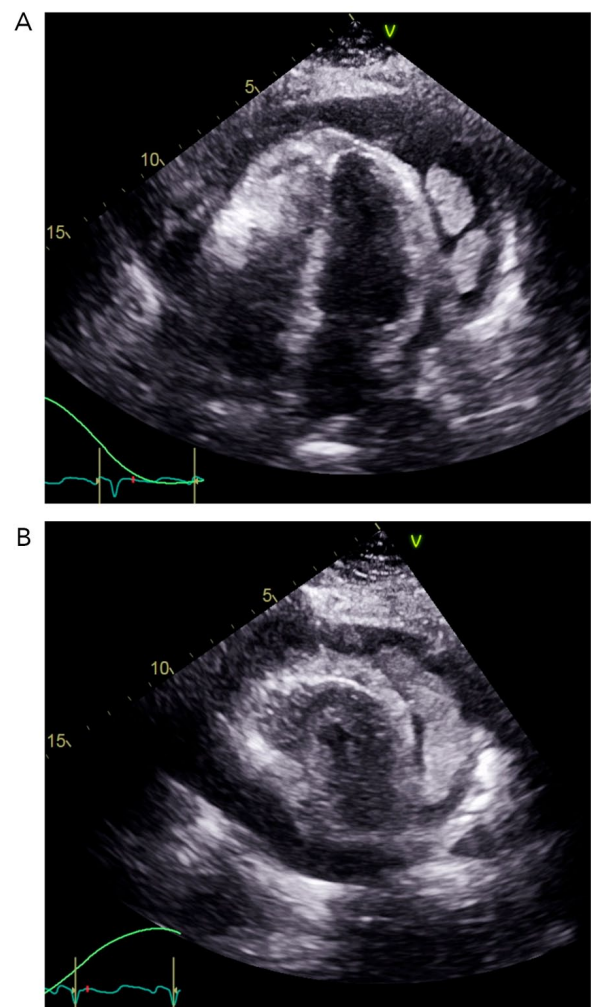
Apical 4 chamber (A) and parasternal short axis (B) echocardiogram images show multiple pericardial masses.
